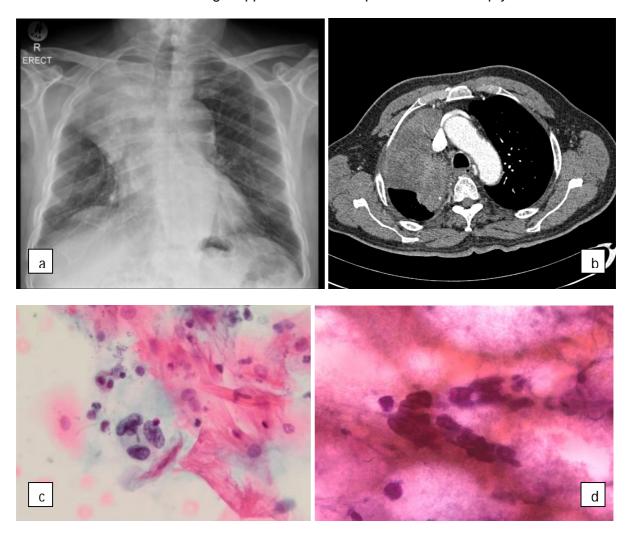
Mass causing obstruction of the right upper lobe bronchus with complete collapse of the right upper lobe on chest X-ray (a) and CT (b). Sputum - malignant. Small balls of cells present with clear, vacuolated cytoplasm and eccentric nuclei suggestive of adenocarcinoma (c). TTNA - Poorly differentiated carcinoma, likely adenocarcinoma (d).
